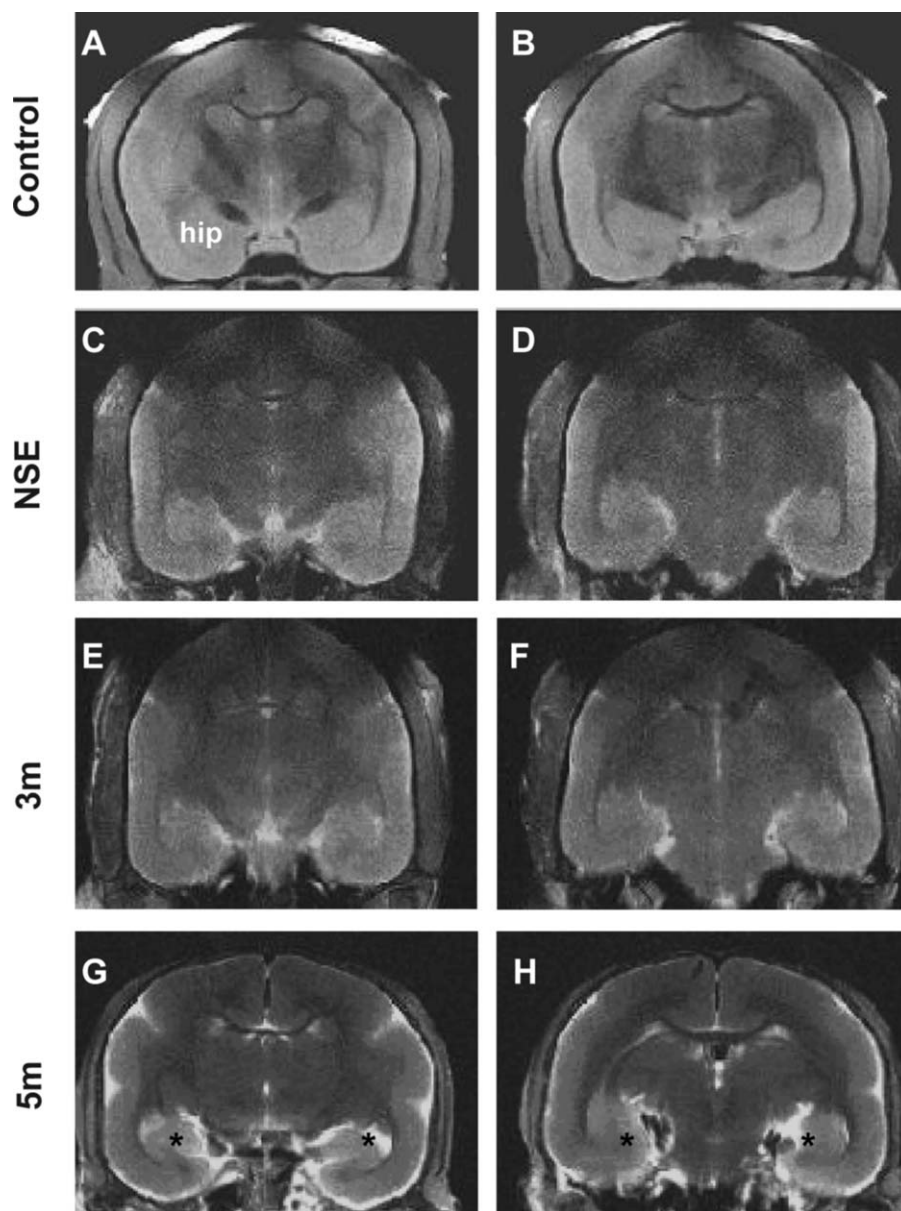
MRI features of marmosets brain during the chronic period after pilocarpine-induced SE. Coronal MRI sections in T2 sequence of control (A and B), NSE (C and D) as well as 3 months (E and F) and 5 months (G and H) after SE. Note the bilateral hippocampal region with hyper signal associated with mesial atrophy in G and H (*); hip: hippocampus.
